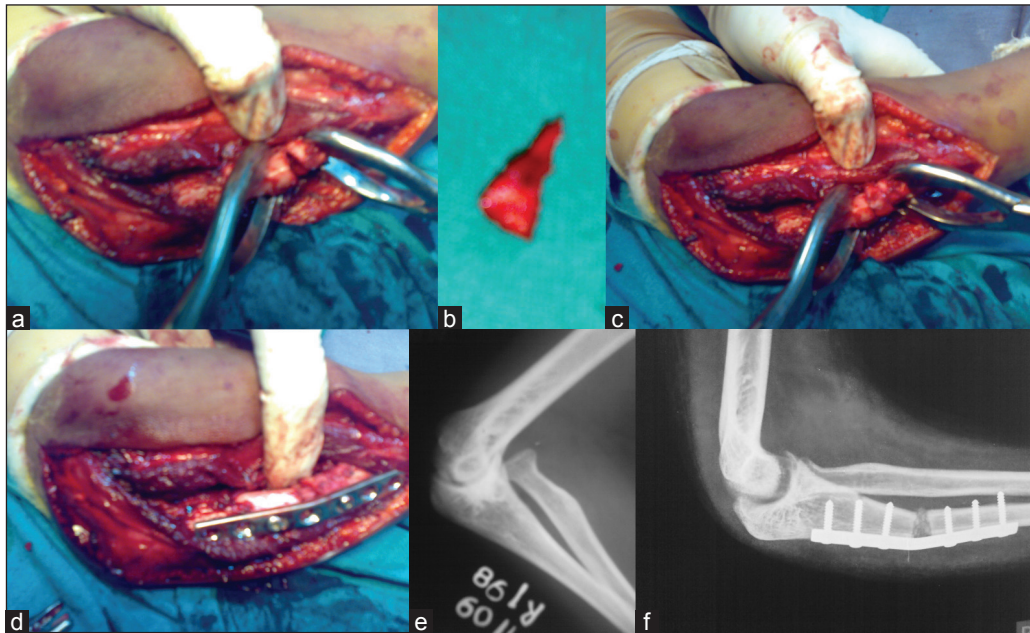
Peroperative clinical photographs (a,b,c,d) and X-rays (e,f) of modified Hirayama's osteotomy with the wedge graft showing (a) Osteotomy followed by bend creating an open wedge. (b) Wedge shaped graft from iliac crest. (c) Graft placed in the open wedge. (d) Osteotomy fixed with a pre bent plate. (e) Pre op X-ray. (f) Post op X-ray
